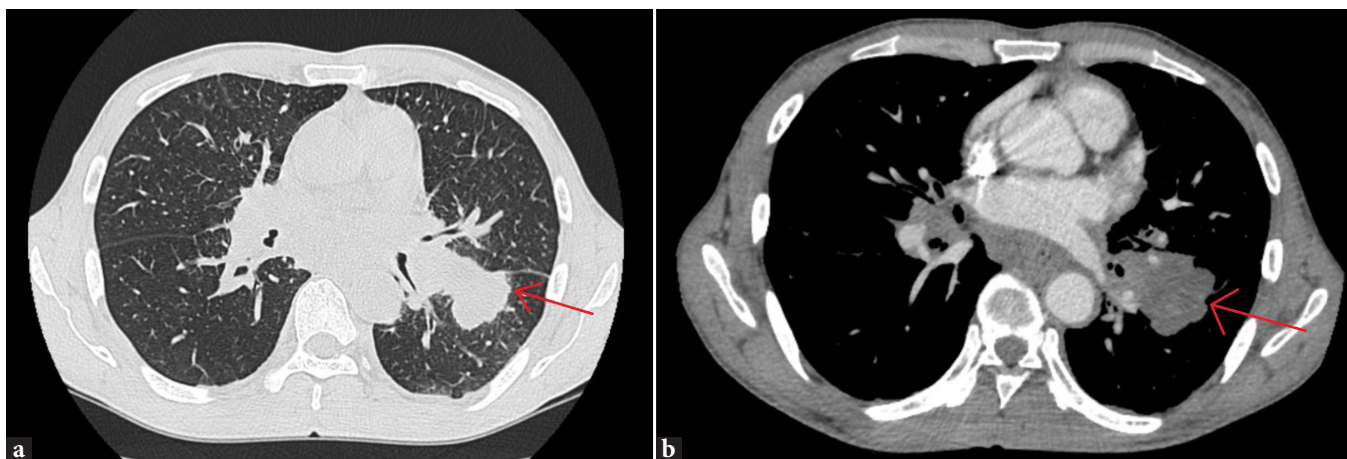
contrast-enhanced computed tomography (CECT) chest images showing lobulated, minimally enhancing, soft-tissue density mass lesions a) Lung window b) Mediastinal window.
